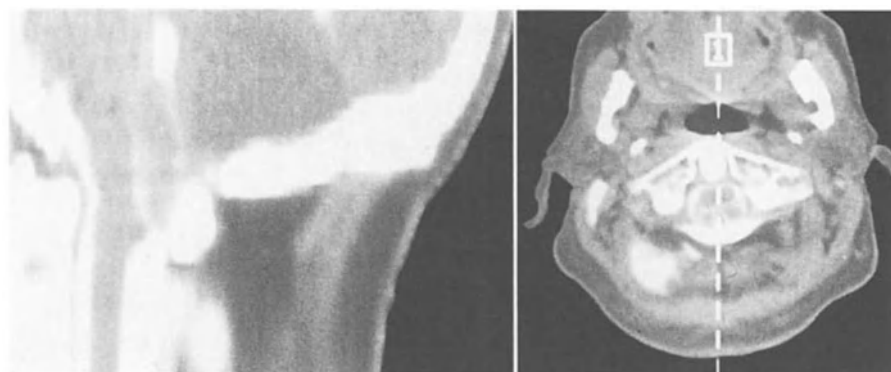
A post myelogram CT of a posterior fossa retrocerebellar pouch in association with a hindbrain hernia. Such pouches commonly fill in the region of the hindbrain hernia. The tonsils fit closely into the foramen closing off the entrance/exit to the pouch. This patient had a complete resolution of his symptoms and his hydrocephalus after radical decompression and re-establishment of a cisterna magna. Note the close fit of the tonsils in the axial cut
